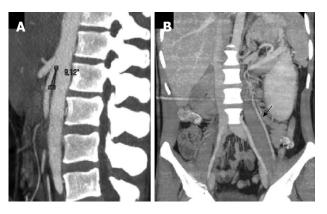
Contrast computed tomography with vascular reconstruction revealing. A: That the aortomesenteric angle was decreased to 9; B: A left renal vein obstruction with left gonadal vein dilatation.
